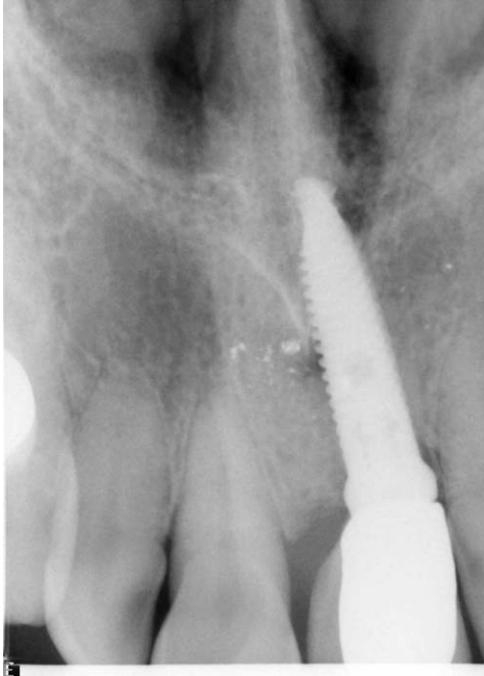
Final x-ray at data collection-3 years after crown adaptation.
